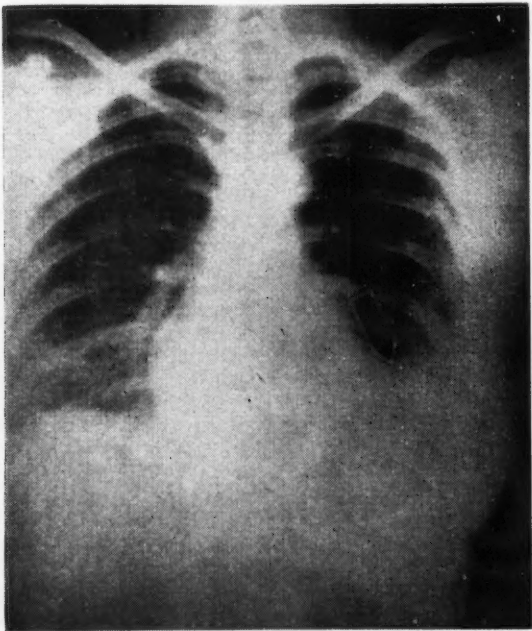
Chest x-ray; basal pleuritic reaction with associated rib fractures; delayed splenic rupture occurring four days later.
